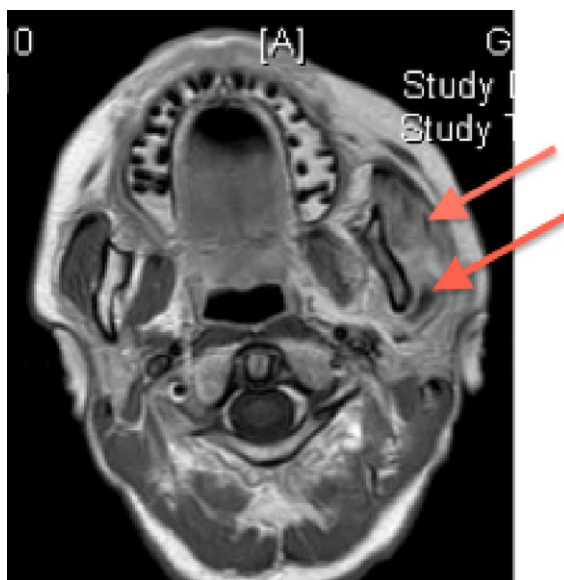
Magnetic resonance image showing inflammation of the masseter (top arrow) and fluid collection caudal to the left TMJ (bottom arrow).
